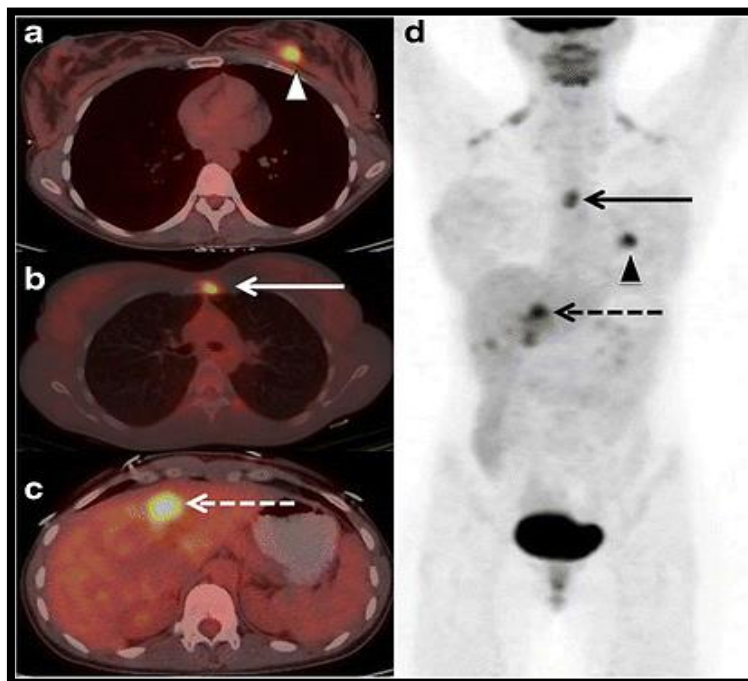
A 29-year-old woman with stage IIA breast cancer was upstaged to stage IV by after doing PET/CT. Axial PET/CT images demonstrated known primary left breast cancer. The arrowhead shows a. the primary breast cancer, while the solid arrow is b. the previously unknown osseous metastasis and c the dashed arrow is the previously unknown liver metastasis. d. The PET gives overview of all lesions (23).
